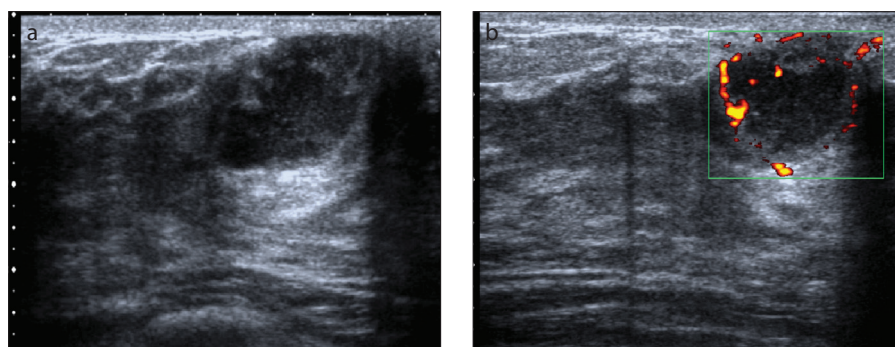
a, b. An 11-year-old girl with a complex cyst with asymmetrical thick wall and irregular margins (a). Power Doppler US (b) reveals intensive vascularity in wall. She had localized pain. Core biopsy from wall of cyst with a 14-gauge needle yielded reactive stromal changes. The diagnosis after needle aspiration was abscess.
